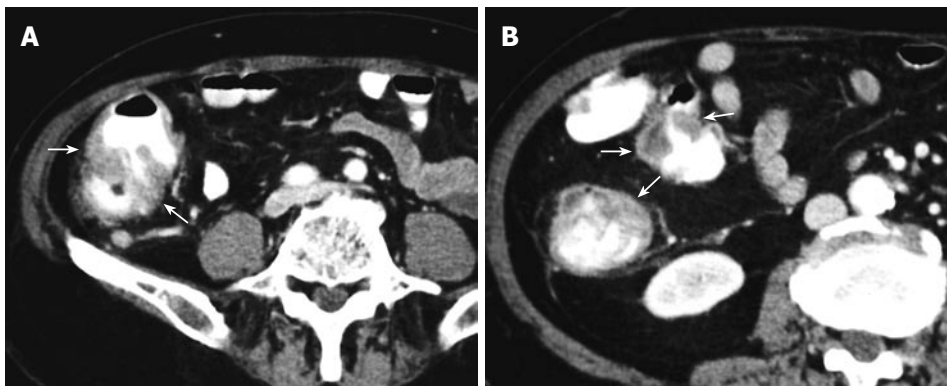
Computed tomographic scans (A, B) of the abdomen. Note the irregular and nodular thickened wall of the cecum and the ascending colon (arrows).
